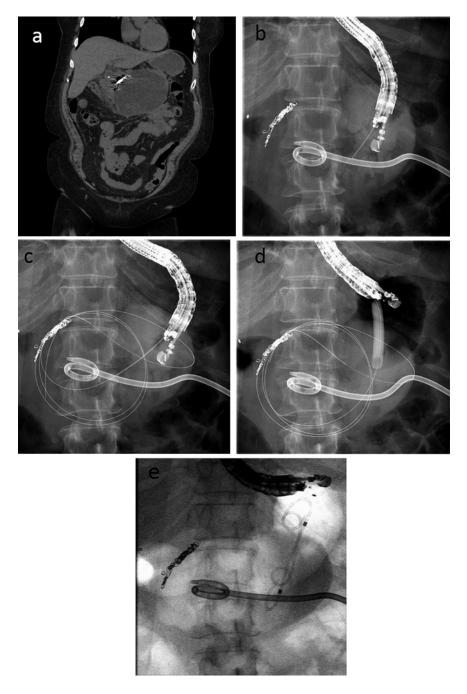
Patient with severe acute pancreatitis with walled-off pancreatic necrosis and disconnected duct syndrome treated with percutaneous drain and transgastric stents. (a) CT demonstrating large WOPN. (b) EUS
